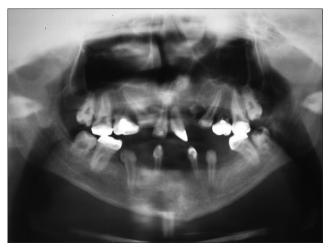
Panoramic radiograph exhibiting hypodontia of maxillary lateral incisors and premolars and mandibular incisors and premolars
